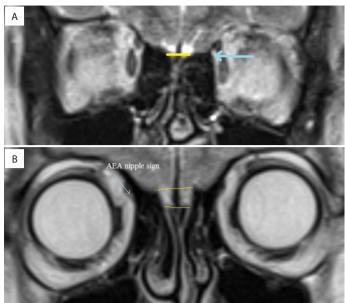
Coronal T2-weighted MR images show that: (a) The entry point of the anterior ethmoidal artery to the nasal cavity (blue line) is at the level of the ethmoid roof (yellow line). (b) The nipple sign showing the entrance point of the anterior ethmoidal artery to the nasal cavity is seen. The entry point is at the top of the ethmoid roof into the nasal cavity.
